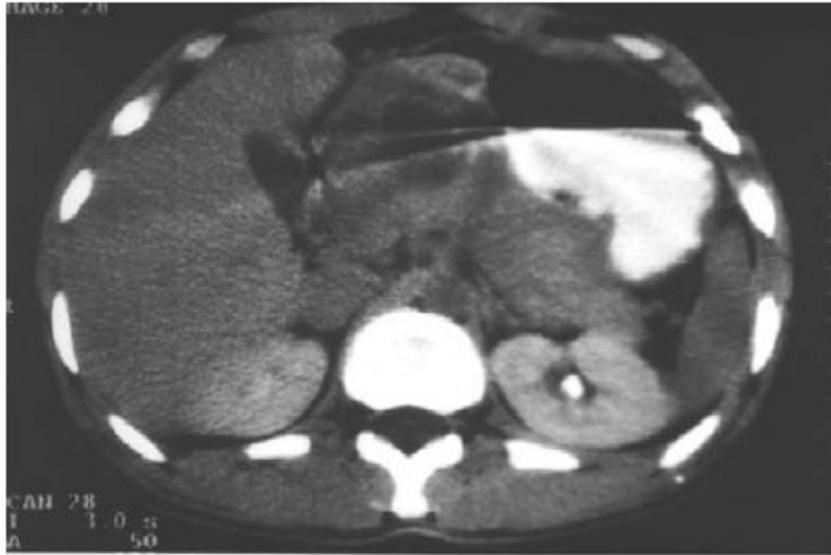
CT of the upper abdomen showing large necrotic inflammatory mass in the lesser sac and involving the pancreas. This was due to perforating gastric TB ulcer.
